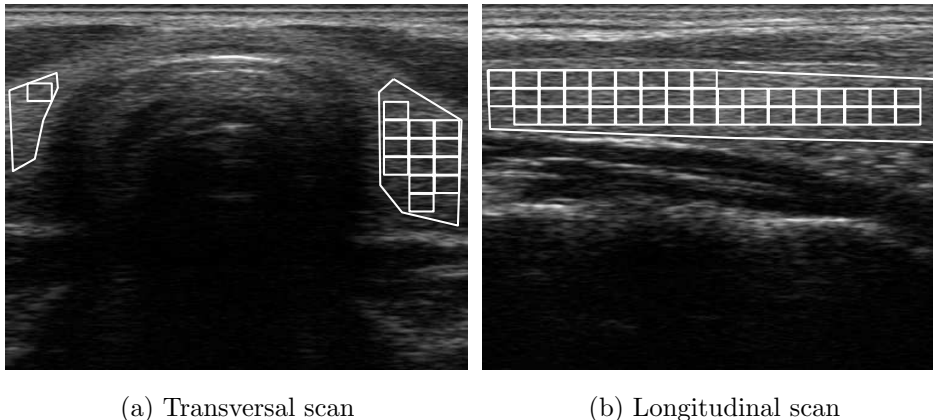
Sonographic images with manually segmented thyroid gland and covered by automatically selected rectangular texture samples.
